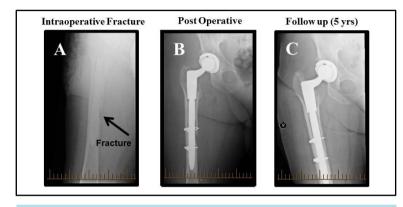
Radiographs of intraoperative fracture during insertion of the stem. A: Intraoperative X-ray after insertion of the stem demonstrates fracture of the femur, B: Postoperative X-ray after treatment of the femoral fracture with cables, C: X-ray after six years follow-up demonstrates united fracture.
